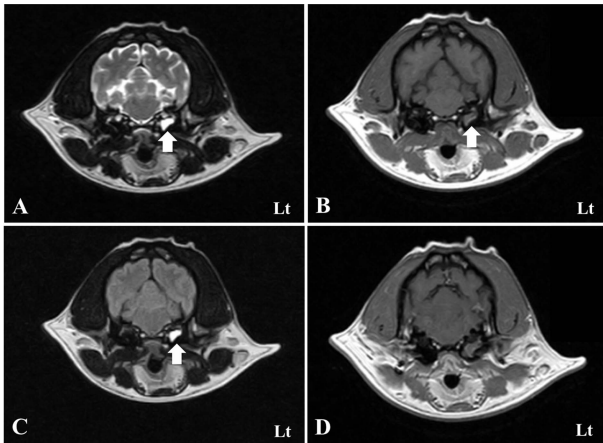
Magnetic resonance imaging findings at the initial examination. A: Transverse T2-weighted (T2W) image. B: Transverse T1W image. C: Transverse fluid-attenuated inversion recovery (FLAIR) image. D: Transverse contrast-enhanced T1W (CET1W) image. The material in the left middle ear was isointense on T1W images, hyperintense on T2W and FLAIR images, and showed no enhancement on CET1W images.
